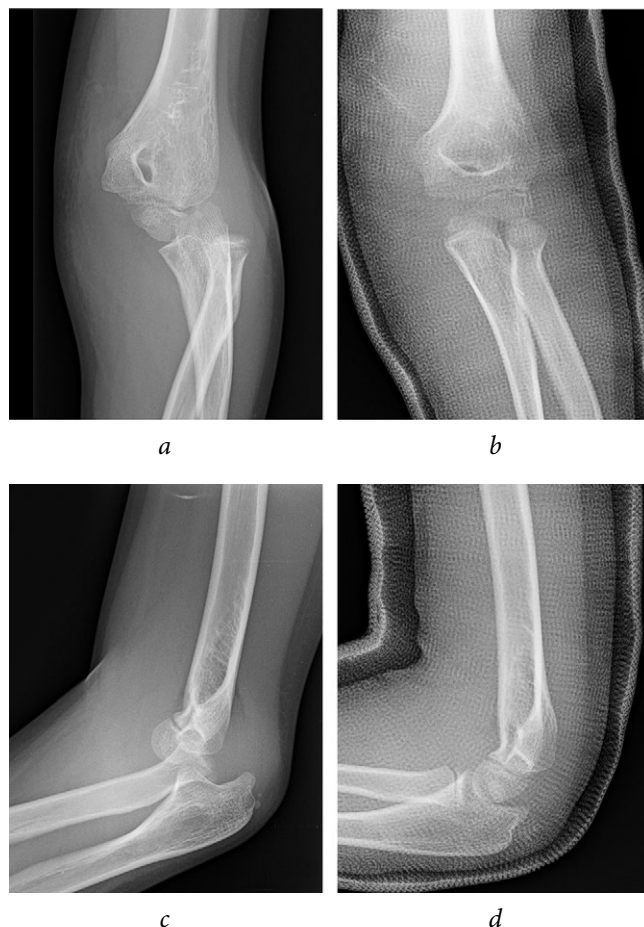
Patient S. Elbow dislocation with ME intraarticular entrapment: *a, b* — X-ray of elbow dislocation; *c, d* — X-ray post-reduction of elbow dislocation with ME intraarticular entrapment
